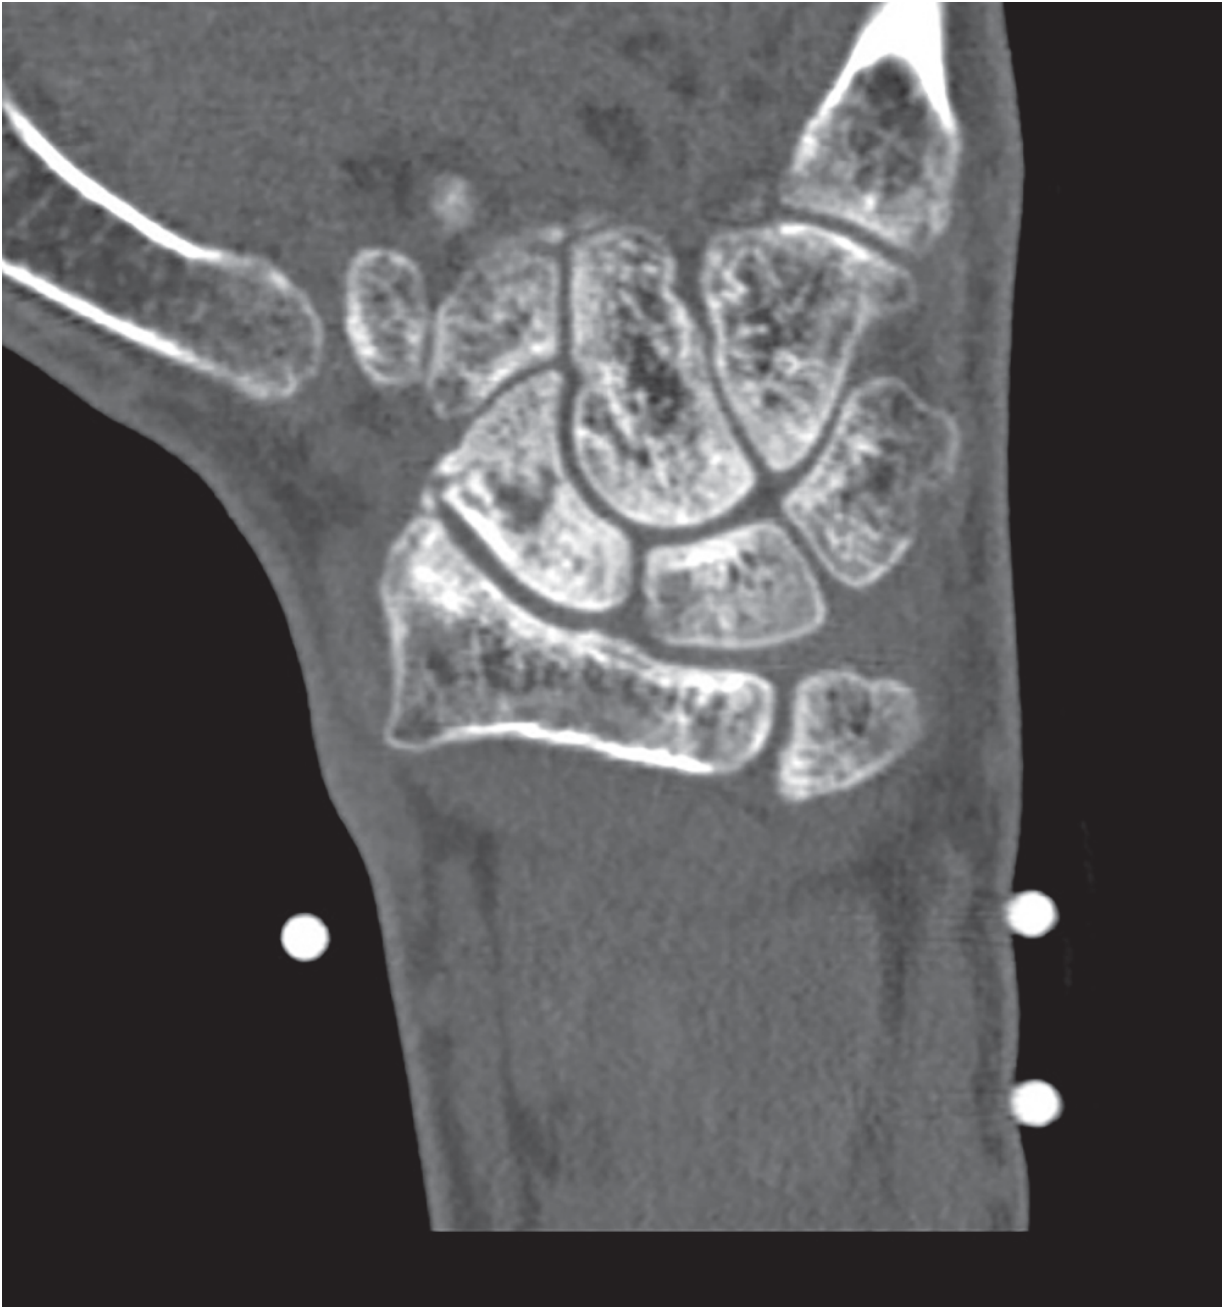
Coronal CT image of the wrist displaying a nonacute fracture of the scaphoid waist extending to the distal pole, with a wide fracture cleft and sclerosis of the fracture surface, confirming scaphoid nonunion.
